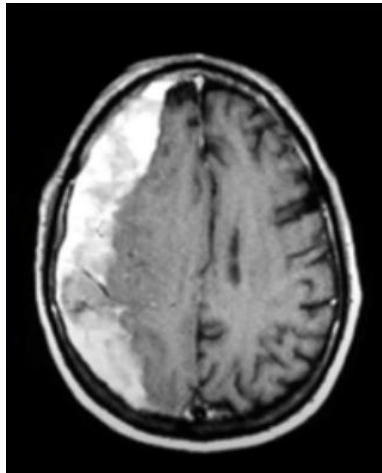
CT scan of subdural hematoma
